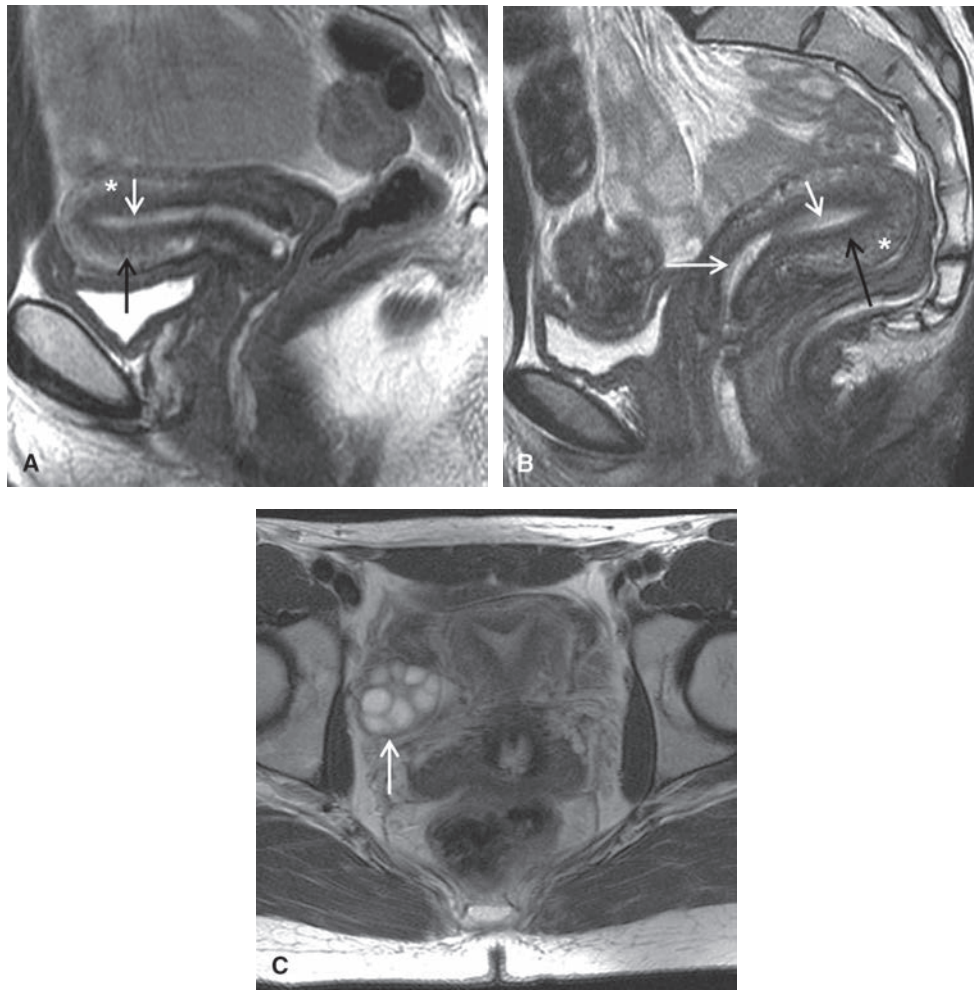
Normal uterus and ovary on MRI. Sagittal (A, B) and axial (C) T2W FSE MR images through the pelvis demonstrate normal uterus (*anteverted* in A, *retroverted* in B) and ovary. The uterine zonal anatomy is seen with the intermediate signal intensity outer myometrium (* in A, B), low signal intensity junctional zone (*black arrow* in A, B), and high signal intensity endometrium (*short white arrow* in A, B). Plicae palmatis are also elegantly demonstrated (*white long arrow* in B) in the cervix. Normal ovary (*white arrow* in C) demonstrates an intermediate signal intensity stroma and multiple high signal intensity follicles.
